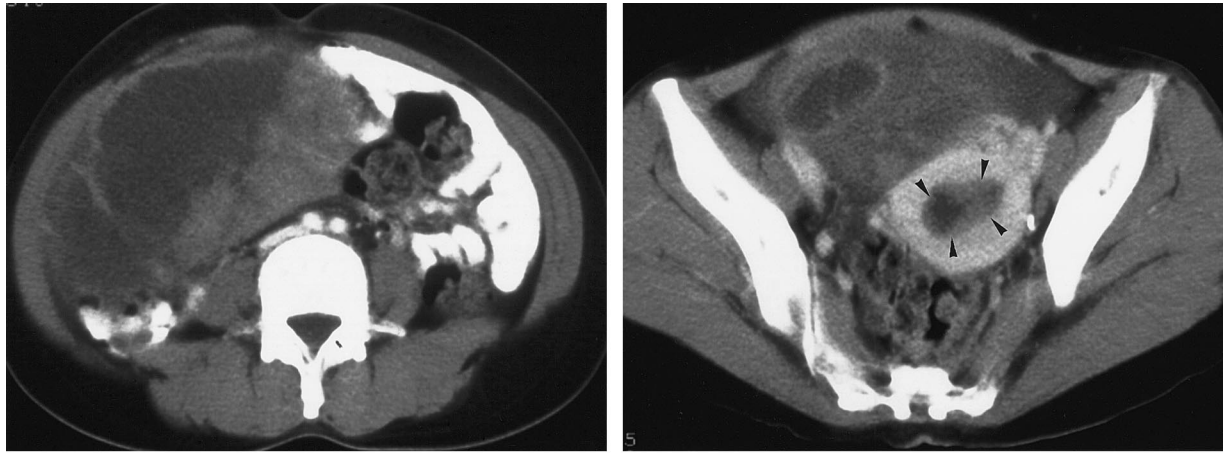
Endometrioid carcinoma of the ovary and endometrial carcinoma of the uterus in a 38-year-old woman. (a) Contrast-enhanced lower abdominal CT scan shows a complex cystic and solid tumor with enhancement of the solid-tissue elements and a thick, irregular wall. (b) Contrast-enhanced pelvic CT scan shows a widened endometrial cavity with a nodular enhancing solid mass (arrowheads).
